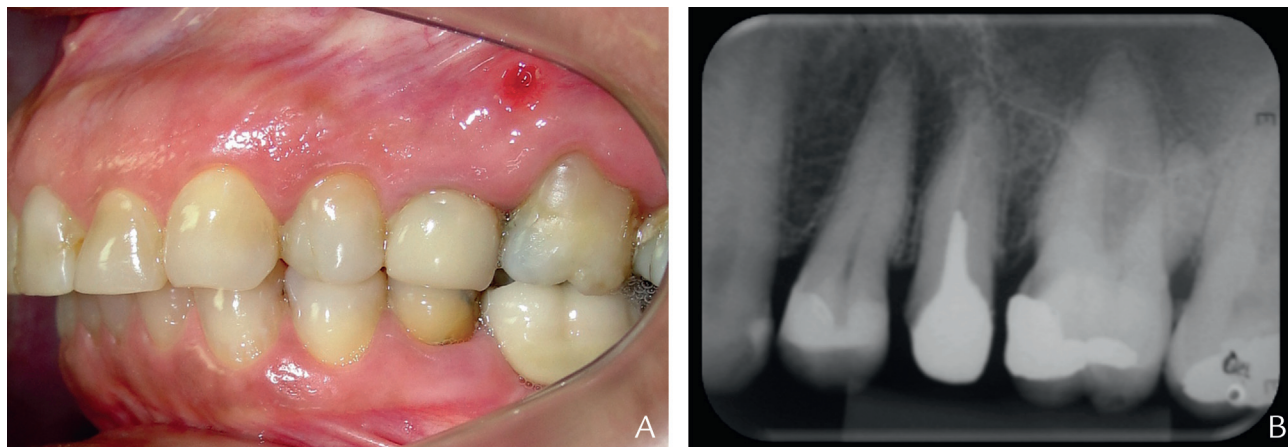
A, Prosthetic rehabilitation after intrusion. B, Periapical radiograph.
